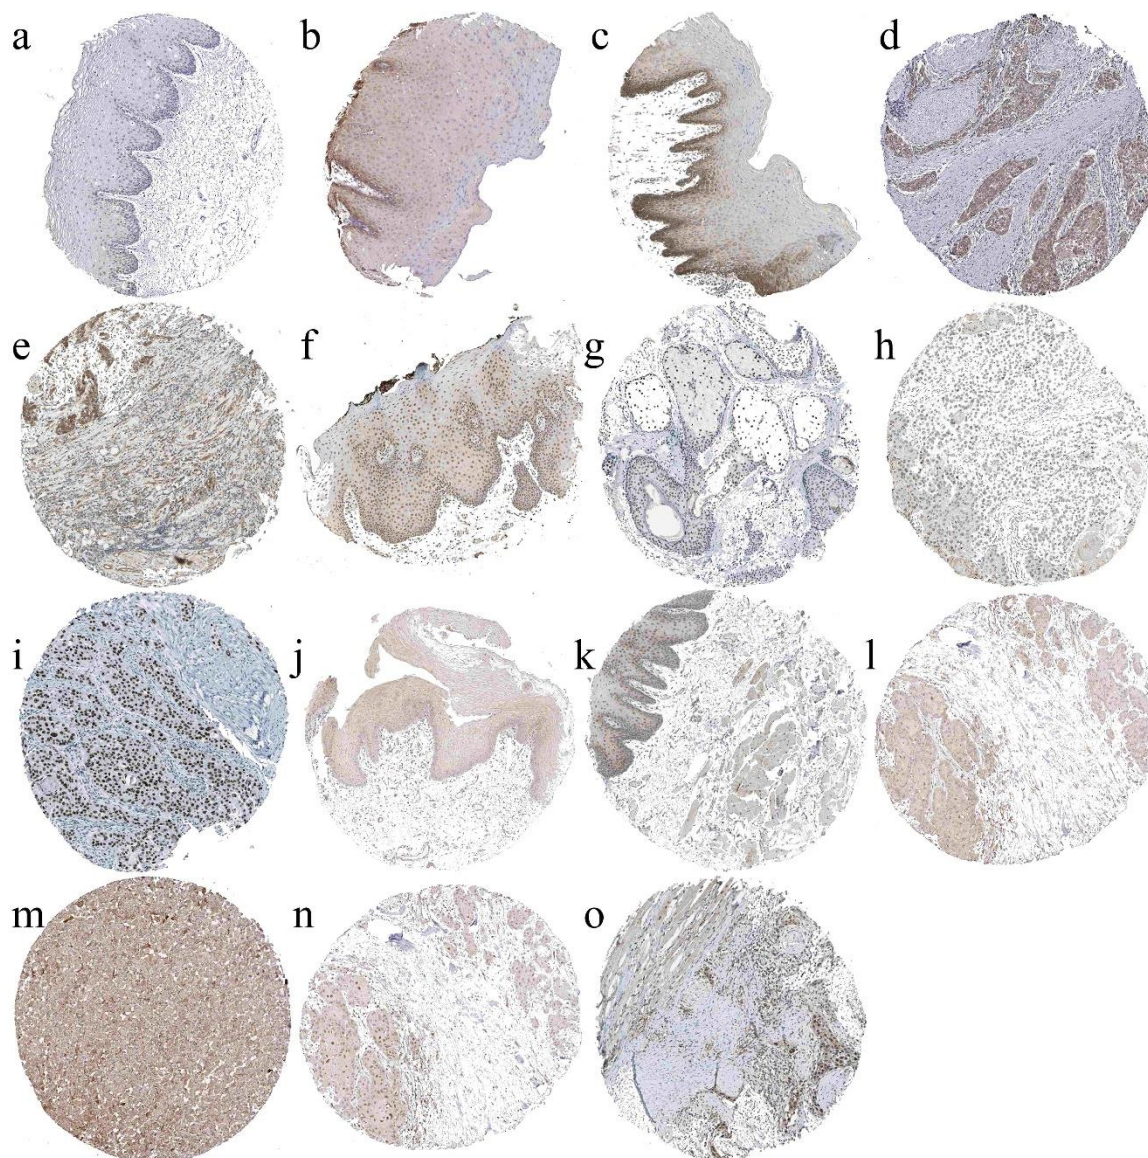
Validation of Prognostic Markers in OTSCC from Protein Expression Analysis in the HPA Database. NME1 expression was not detected in a normal oral mucosa sample (a). Intermediate (b) and high (c) expression levels of NME1 in normal samples. Moderate (d) and high (e) NME1 expression levels in HNSCC samples. Low (f) and high (g) expression levels of TOP1 in normal oral mucosa samples. TOP1 expression was low (h) and high (i) in HNSCC samples. The expression of PSMA4 was not detected (j) and low (k) in normal oral mucosa samples. The expression levels of PSMA4 were not detected (l), low (m), medium (n), and high (o) in cancerous samples. HPA, human protein atlas.
